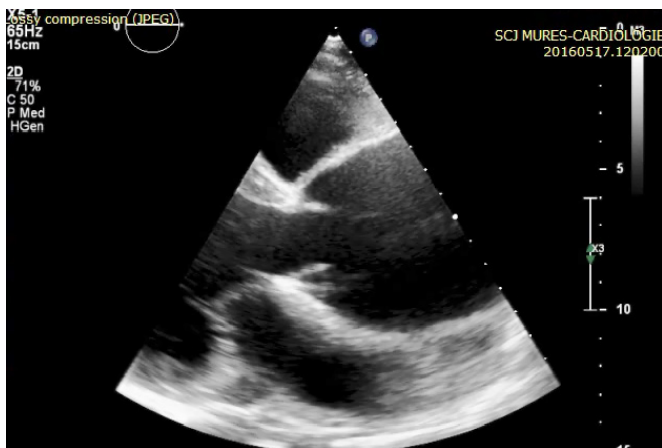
2D transthoracic echocardiography - parasternal long axis view of the ascending aorta: severe dilatation
